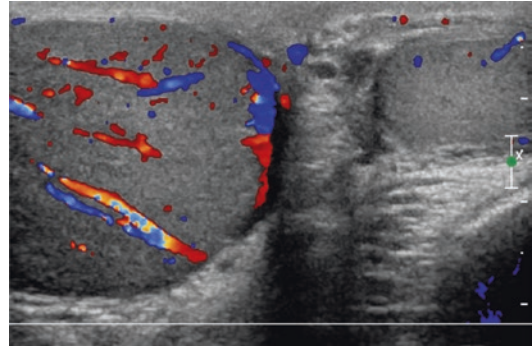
Primary diffuse large B-cell lymphoma of the right testis. The patient presented with progressively enlarging, painless right scrotal lump. The right testis was markedly enlarged and hard at palpation. Color Doppler interrogation shows diffuse involvement of the right testis by hypervascular lymphoma tissue with no circumscribed nodules. Normal testicular vessels are shown with normal course running into the tumor tissue. The left testis is normal
